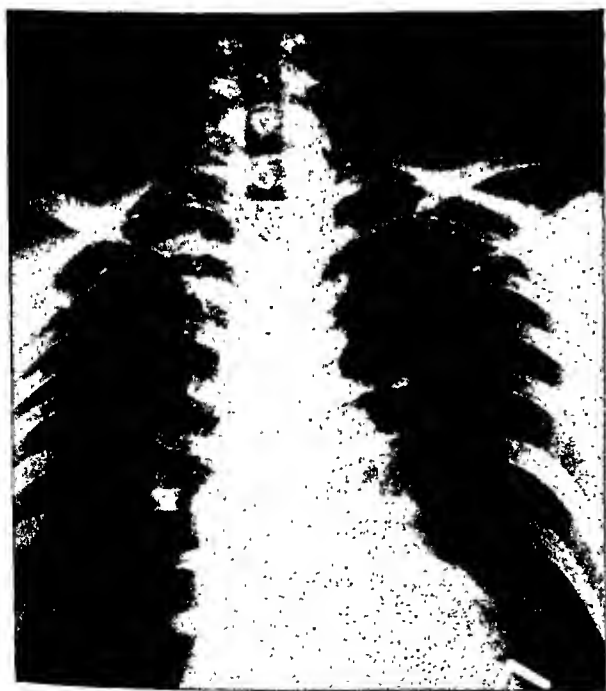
Prominence of the sternal end of the left clavicle (arrow) secondary to scoliosis in the cervicodorsal region. The medial aspect of the left clavicle lies at a distinctly higher level than the right. The patient had noted prominence in the left sternoclavicular region and had consulted her physician as she feared a malignant lesion. The doctor made a diagnosis of "probable neoplasm." Roentgen demonstration of the cause of the condition relieved her fears.
